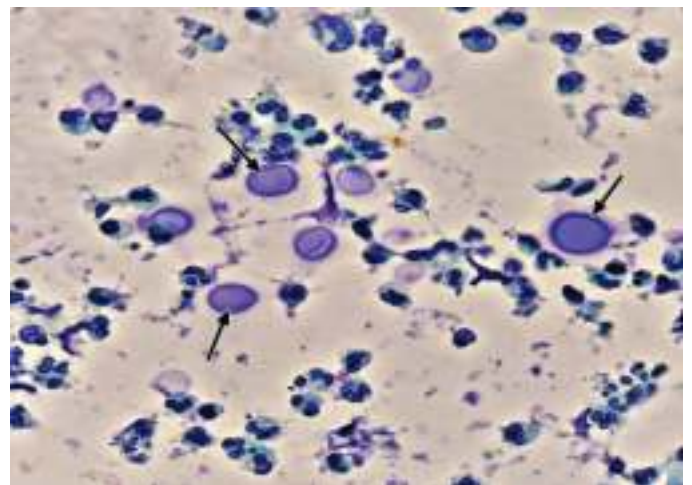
Cryptococcus neoformans*. Endobronchial ultrasound bronchoscopy (EBUS) demonstrates *Cryptococcus neoformans* (arrows) (400X). (Courtesy: Dr. Tushar Kalonia.)
